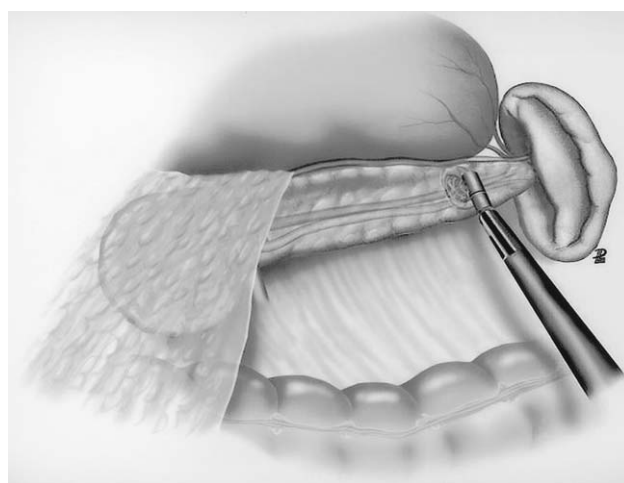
Patient placed in half-lateral position with left side up for tumor located in the body-tail of the pancreas. The anterior aspect of the pancreas is exposed for laparoscopic ultrasonographic study.
